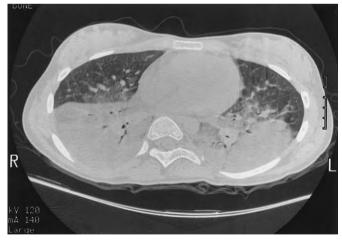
Computed tomography scan through the midthorax of the same patient as in Figure 25-1. The density of consolidation measured -35 to -40 Hounsfield units, which is consistent with lipoid pneumonia.
